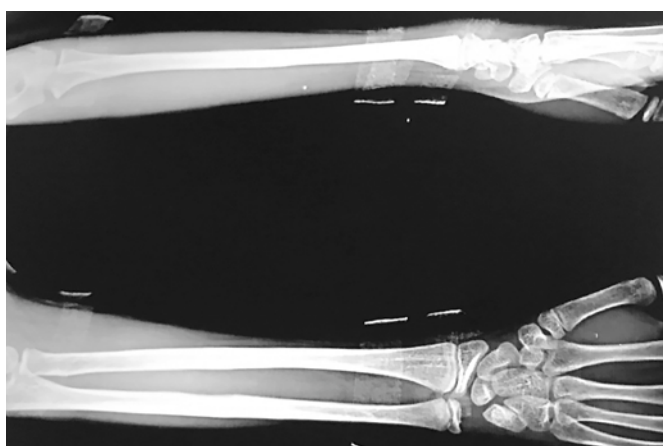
X-ray of forearm after implant removal
